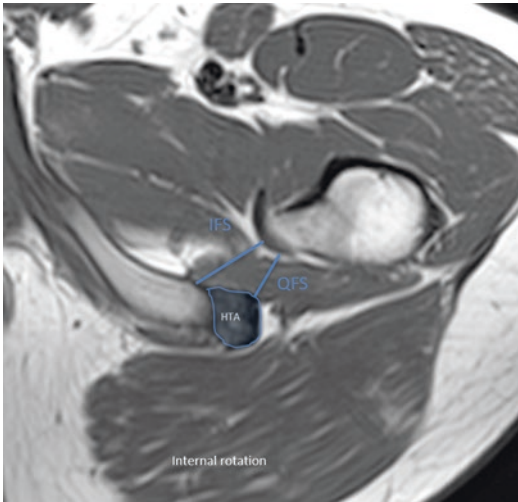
Axial T1-weighted magnetic resonance (MR) image at the tip of the lesser trochanter (LT) in internal rotation shows normal left ischiofemoral space (IFS), quadratus femoris space (QFS), and hamstring tendon area (HTA). IFS is defined as the gap between the ischium tuberosity and the iliopsoas tendon, and the LT and QFS as the smallest gap between the superolateral surface of the hamstring tendons and the posteromedial surface of the iliopsoas tendon or the LT
